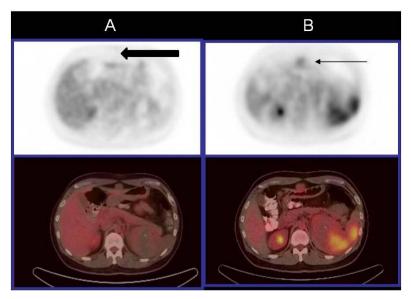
(A) Peritoneal nodule seen on CT without FDG uptake. (B) Additional delayed images only of the abdomen show increased uptake in the peritoneal nodule, consistent with malignancy. Biopsy confirmed peritoneal carcinomatosis.
